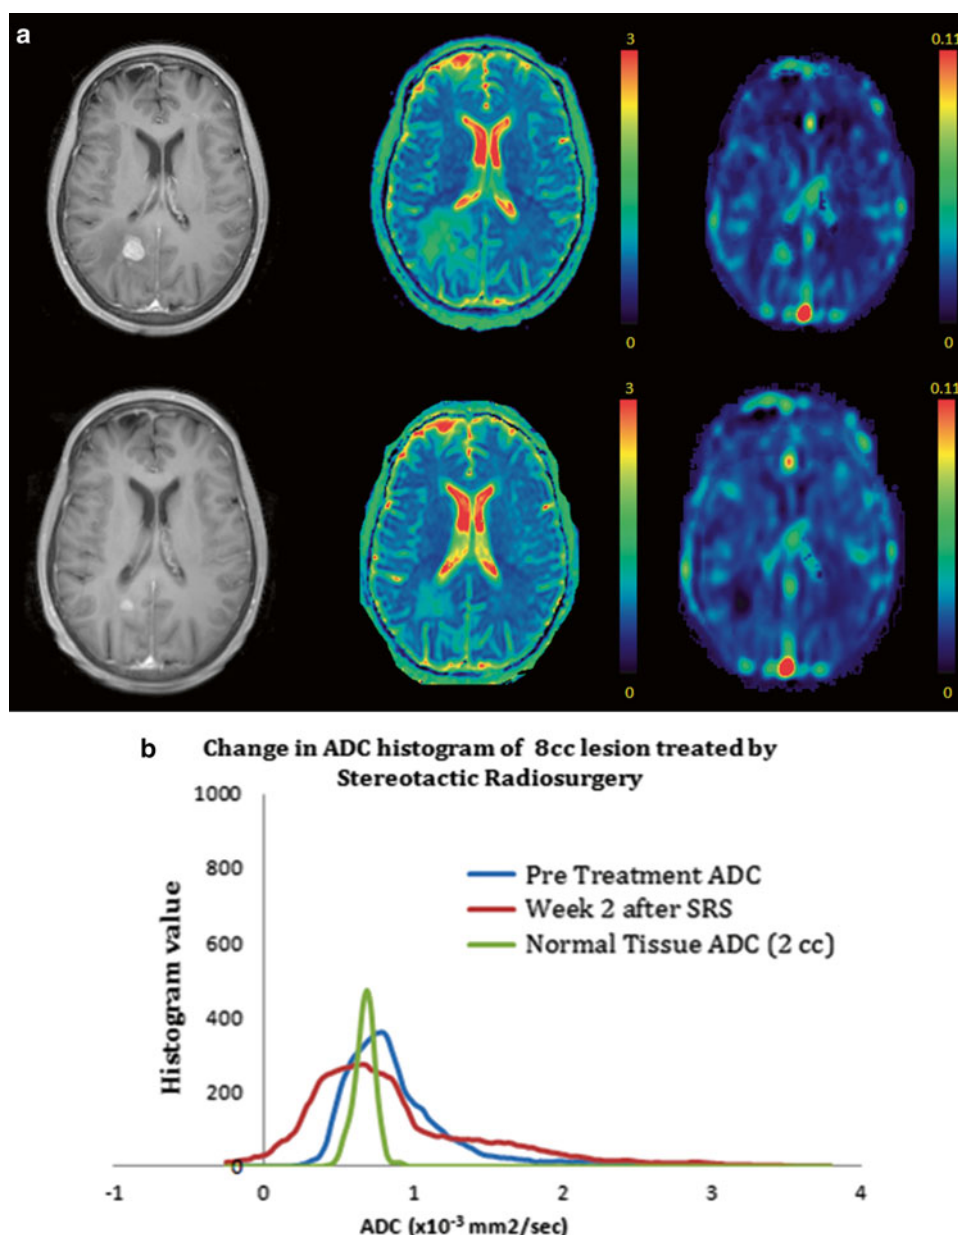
(a) T1-weighted images (*right*), ADC map (*middle*), and perfusion map (*left*) are shown at baseline prior to SRS for a right parietal brain metastases (*top row*) and 1 month post SRS treatment (*bottom row*). Qualitatively, there are significant decreases noted in tumor volume, diffusion, and perfusion 1 month after treatment. (b) Mean ADC histogram analyses performed for the normal tissue
